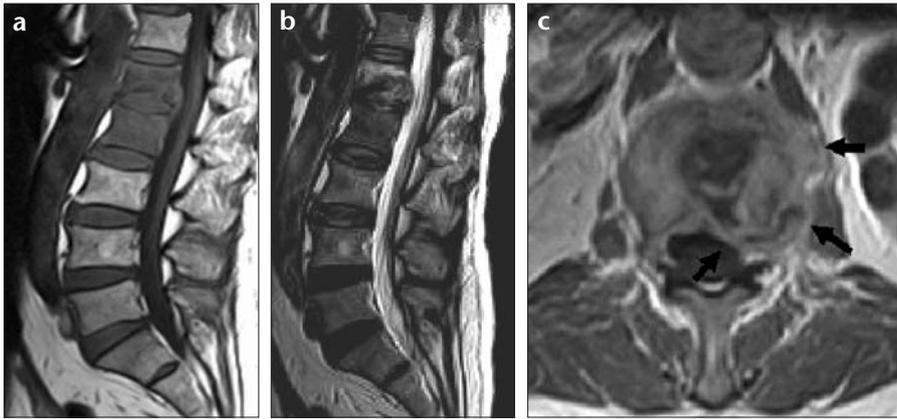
a-c. Tuberculous spondylodiskitis. Sagittal T1-weighted (a), T2-weighted (b), and transverse post-contrast T1-weighted (c) TSE MR images of the lumbar spine show spondylodiskitis at the L1-L2 level. Contrast enhancing epidural and left paravertebral abscess is also noted (arrows).
